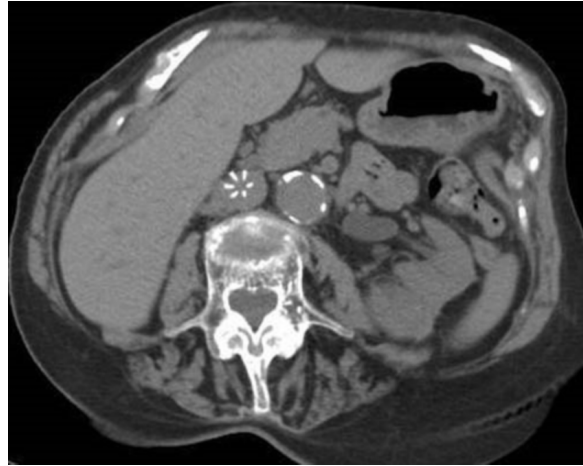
Unenhanced CT of the left kidney at the level of the excised mass, 11 months following tumor excision. The scan is at the same level as Figures 1 and 2. The three small densities seen in Figure 2 are no longer present.
